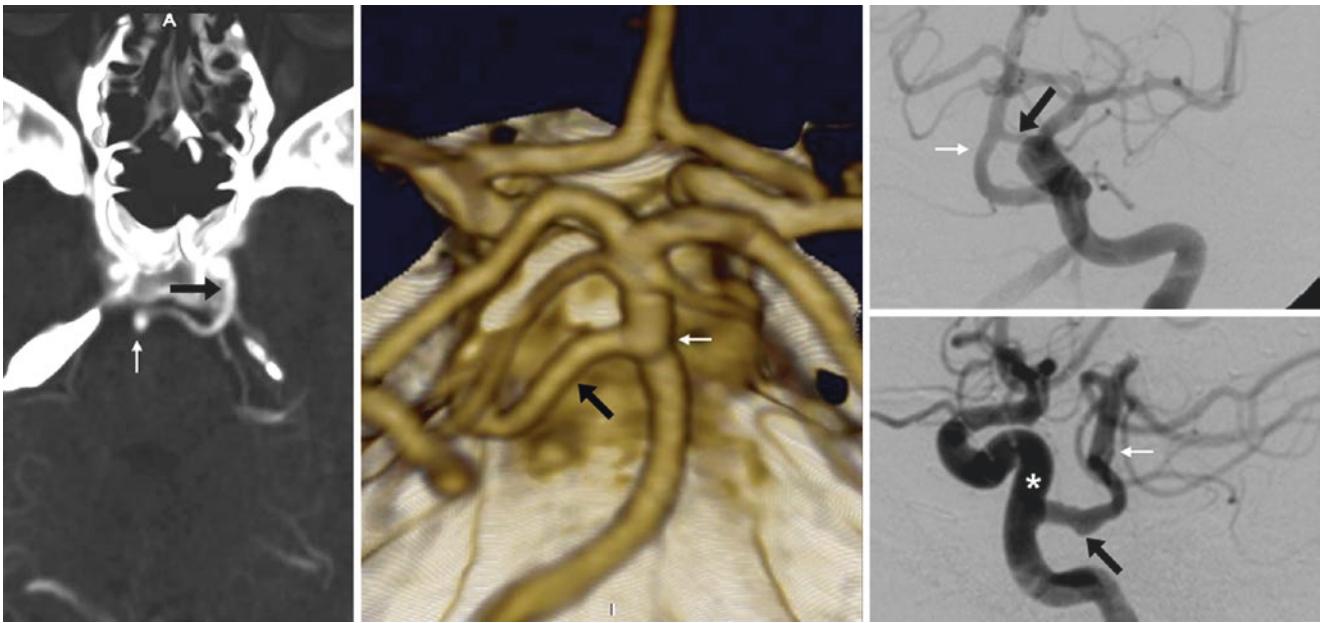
In this 64-year-old, an axial source CTA 9-mm MPR image (left) depicts a PTA (black arrows) travelling lateral to the sella from the cavernous left ICA and terminating in the mid-basilar (thin arrows), as seen on a 3D VR PA view (middle). The PTA fills from the left ICA (asterisk) on DSA AP (right, top) and lateral (right, bottom) runs
